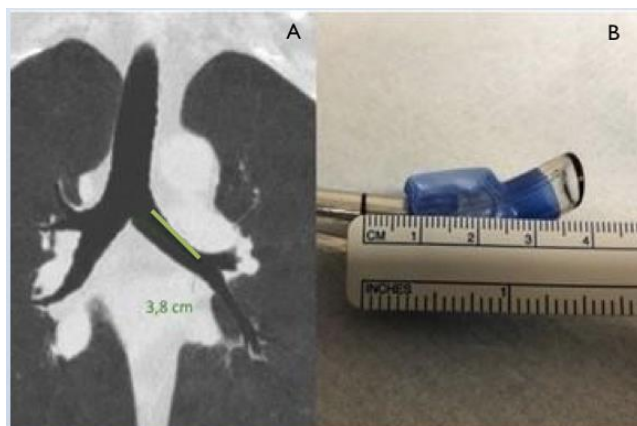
Measure of the left main bronchus on CT-scan reconstruction (A) and direct measure of DLT extremity length (B)
